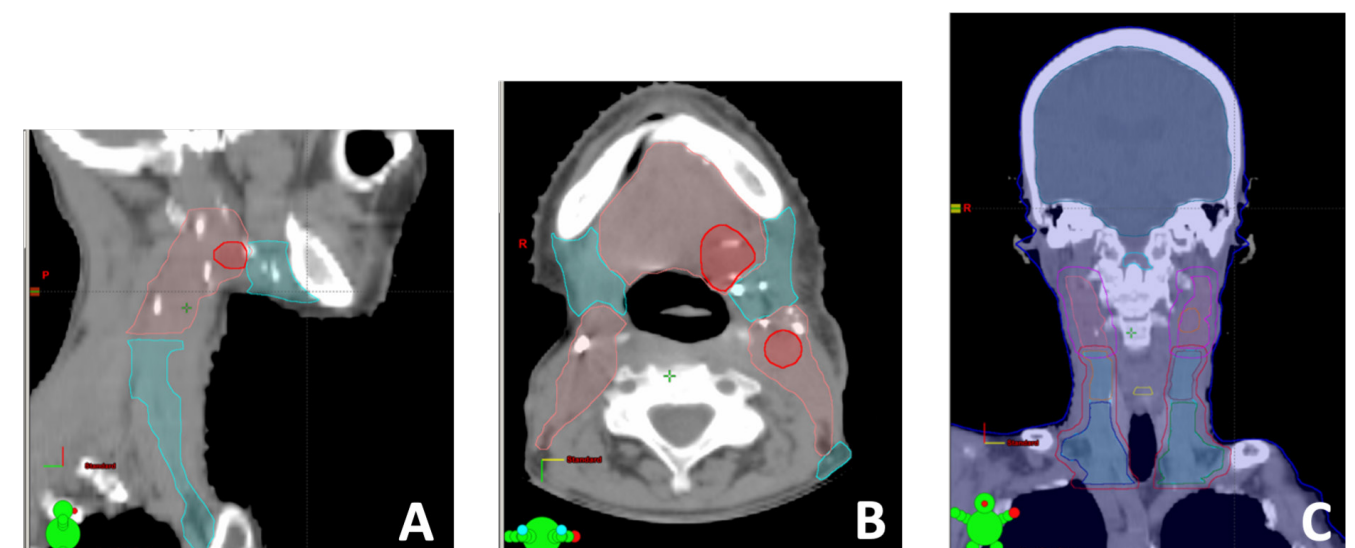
CT scan of lower neck region with indicated contouring for treatment planning. (A) inferior transverse CT image immediately inferior to mandible: differentially contoured fields indicate varying dosage. Bright red regions will receive the highest dosage of radiation (66 Gy), whereas blue regions will receive the lowest (54 Gy). (B) right mid-sagittal CT image showing lymph node cluster 2 marked for high dosage as well as other neck regions that contain lymph node clusters 3 and 4. Lymph nodes 3 and 4 require less radiation due to less metastatic presence as indicated via FDG-PET. (C) anterior coronal CT image of head and neck. The left, most superior field includes the previously mentioned high dosage hotspot for lymph node cluster 2.
